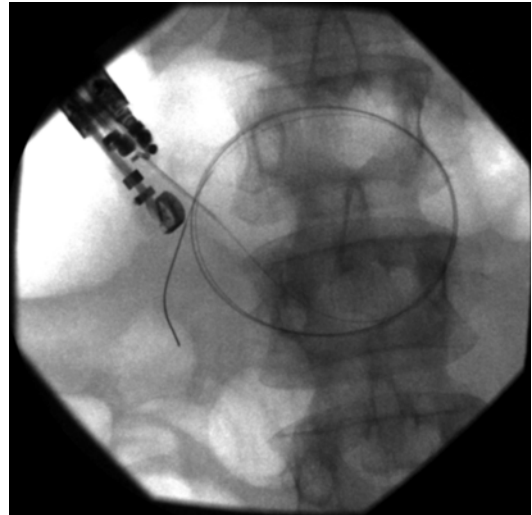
Endoscopic ultrasound-guided transgastric puncture of WON
